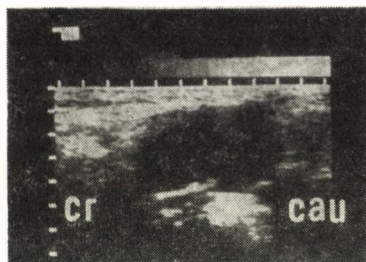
Sonography of the patient mentioned in Fig. 3 made one year later demonstrates well the pseudoaneurysm in front of the vessels in the left inguinal fold (cr = cranial, cau = caudal directions)
